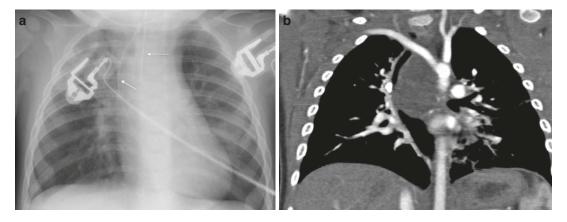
Abnormal course of the NG tube. (a) Deviation of the NG tube suggesting mass effect. (b) CT confirms the presence of a mediastinal mass
